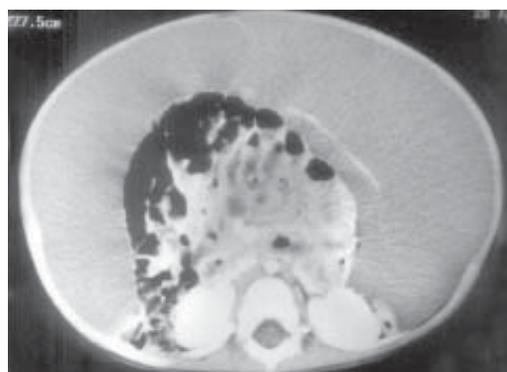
CT scan of abdomen shows gross ascites (23 HU) with few septations within. Bowel loops are clumped together posteriorly in the central abdomen.
